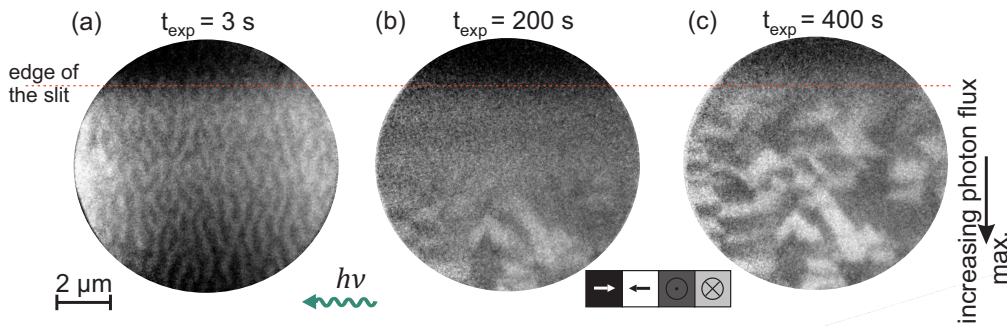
Snapshots of XMCD-PEEM imaging of domain structure of the inverted sample, acquired after different x-ray exposure times t_{exp} at 0 kV m^{-1} applied across the PMN-PT substrate and at zero applied magnetic field. Note that the black/white contrast in (a) is enhanced on purpose for better visibility of the domains.
